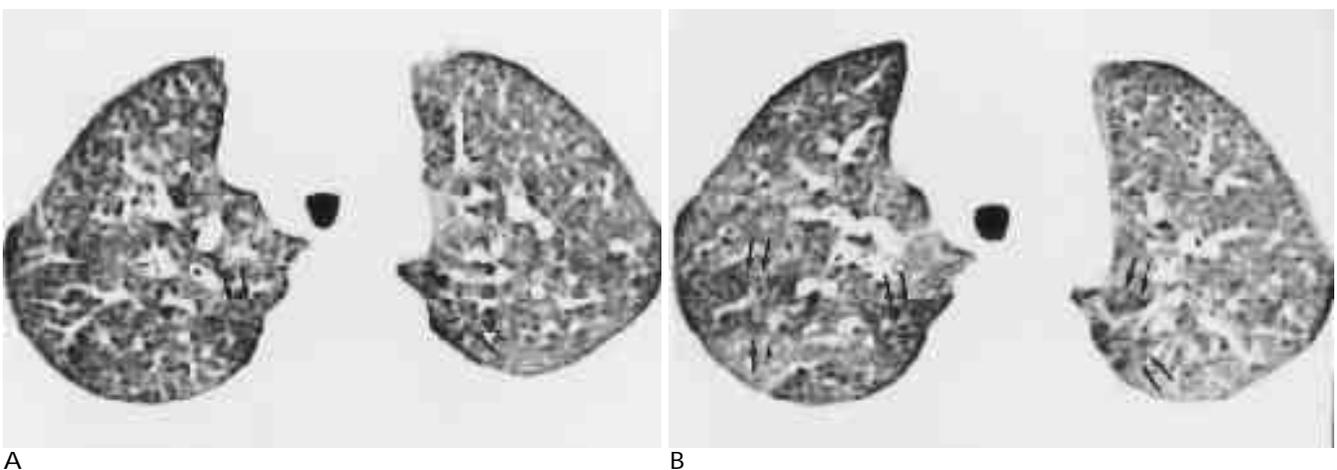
HRCT scan through the right upper lobe in a 3 year - old male. Focal area of hyperlucency, most likely representing air trapping are seen in the both upper lobe (A, arrows), which is more prominent in expiratory scan (B, arrows).
